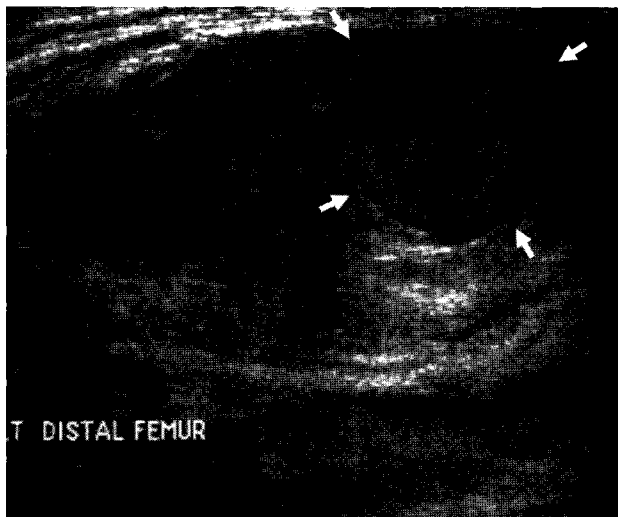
Sonography revealed a hyperechoic round mass (arrows) measuring approximately 2.3 cm in diameter, which represented a pseudoaneurysm filled with thrombi. Duplex color Doppler sonography showed the swirling blood flow characteristic of a pseudoaneurysm within the mass.
